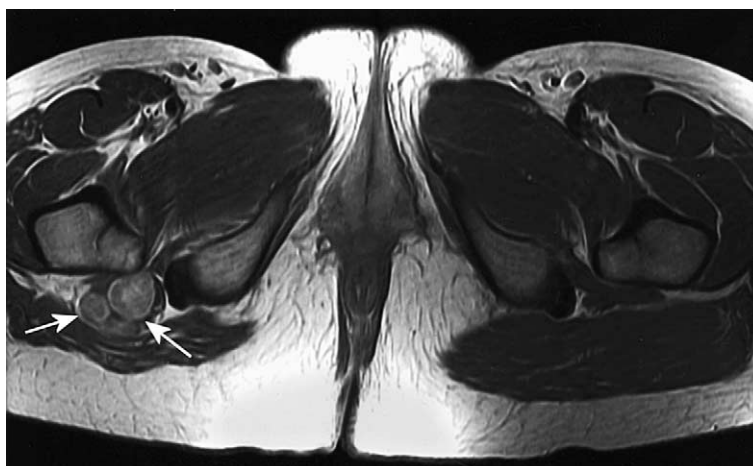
T1WI axial MRI of the right sciatic nerve: the lesions appear to be well encapsulated – consistent with schwannomatosis rather than neurofibromatosis.
